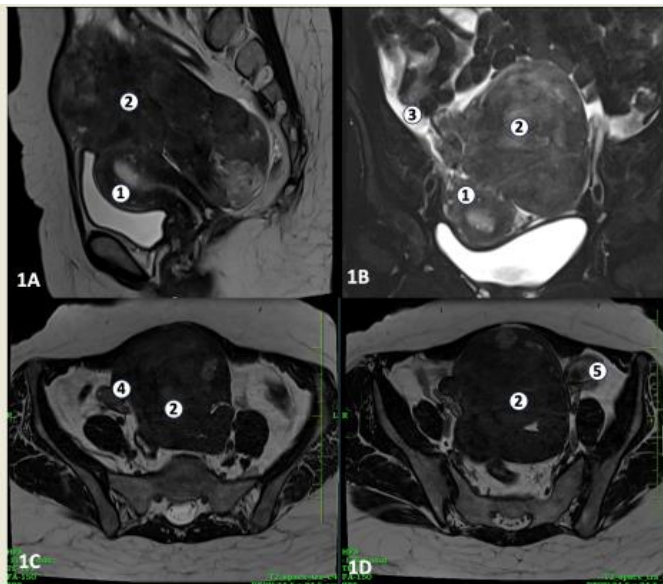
T2 sagittal, axial and Coronal MRI images 1A) T2 sagittal image showing a large well differentiated heterogenous mass lesion in the midline pelvis. The lesion is seen abutting the uterine fundus and posterior myometrium with well-maintained fat planes. 1B) T2 coronal image showing free fluid in the abdomino-pelvic cavity, suggestive of mild ascites. 1C) T2 axial image showing Right and 1D) left ovaries separately. (Marked areas in the figure – 1. Uterus, 2. Heterogenous Mass, 3. Ascites, 4. Right Ovary, 5. Left Ovary)
